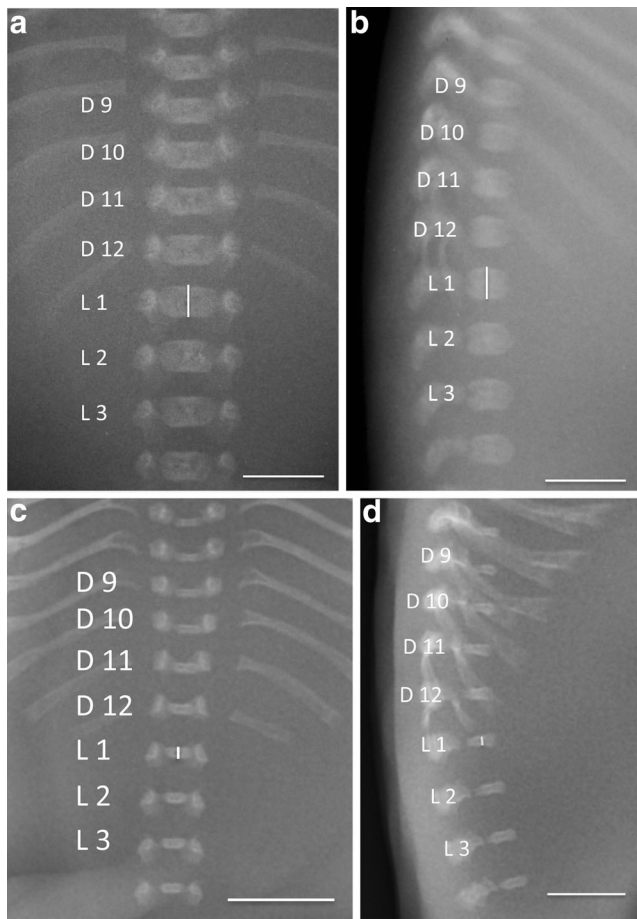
a, b Control spine X-rays in antero-posterior and lateral projections (gestational age 17 weeks). The ossified anterior vertebral body is egg-shaped. The height of each body was measured on the median vertical line and reported as the mean of those of the two projections ($bar=5$ mm). c, d TD spine X-rays in antero-posterior and lateral projections (gestational age 21 weeks). The ossified anterior vertebral body is flattened on the vertical line, but there has been no such evident developmental inhibition in the transverse plane ($bar=5$ mm)
